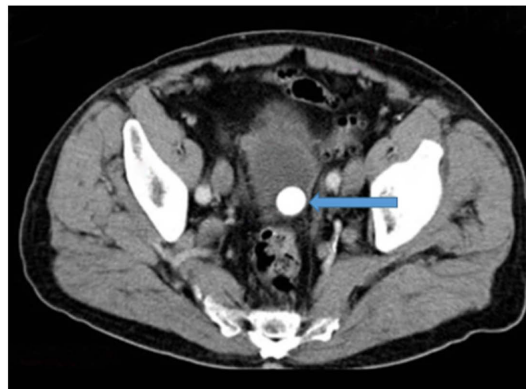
Uro-CT in axial section without injection of contrast medium, parenchymal window: bladder lithiasis (arrow).
